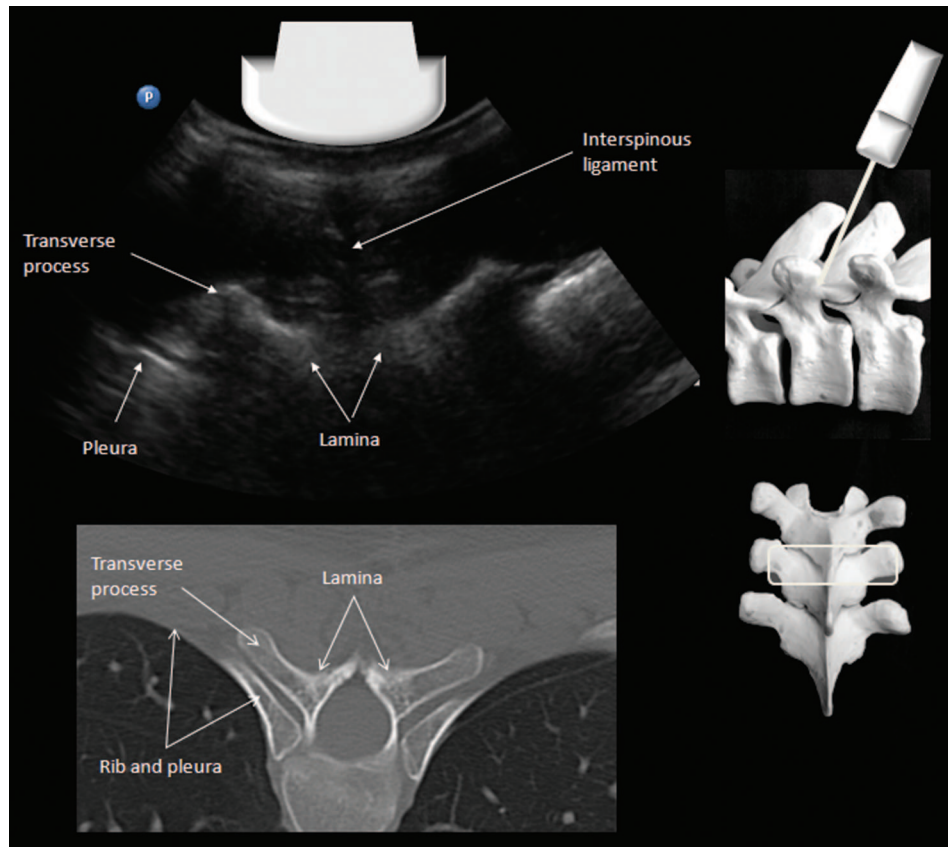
Transverse interspinous view of the midthoracic spine and corresponding computed tomography image (bone window). An interlaminar view into the vertebral canal cannot be obtained because of the steeply sloping spinous processes and overlapping laminae. (Image used with permission from www.usra.ca.)
